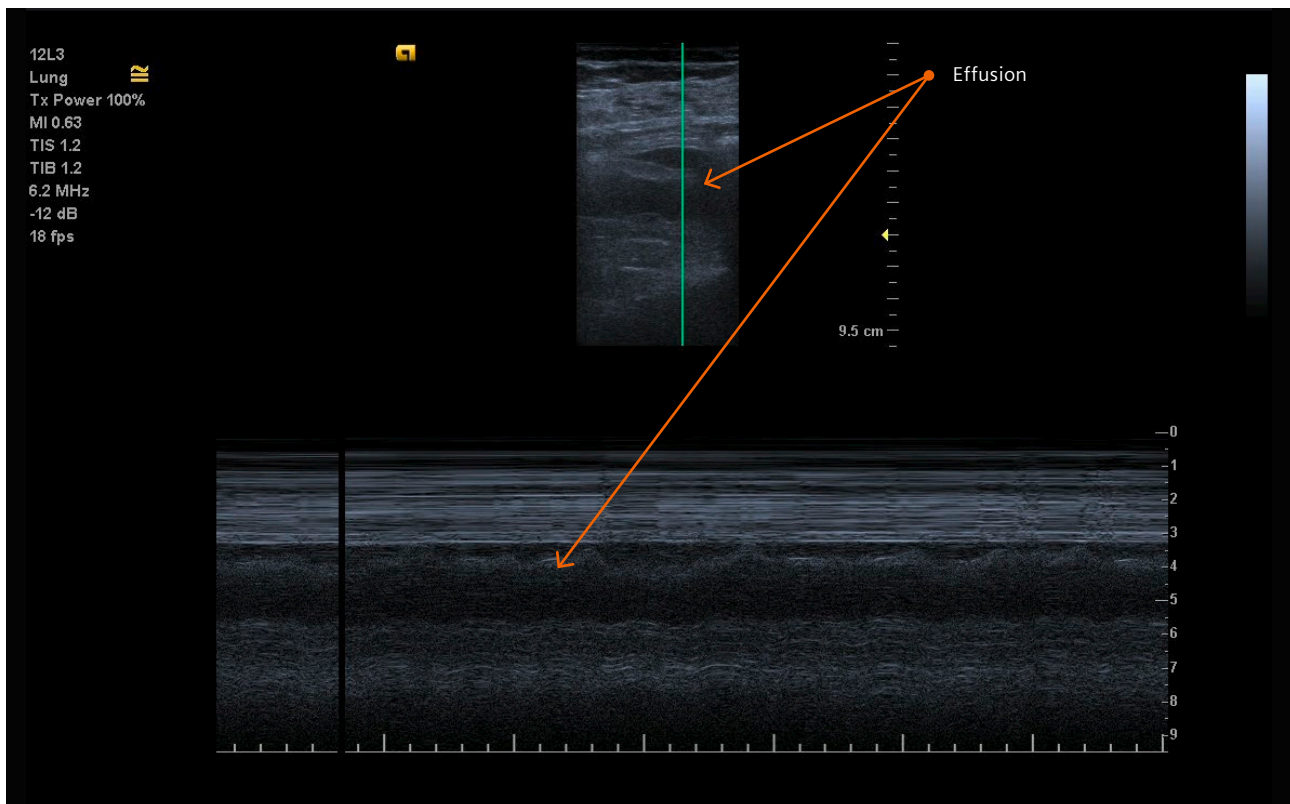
COVID-19 pneumonia. Follow-up examination in the ICU using a linear (12–3 MHz) transducer including M-mode and B-mode. Ultrasound findings detected pleural thickening and an additional small pleural effusion.
